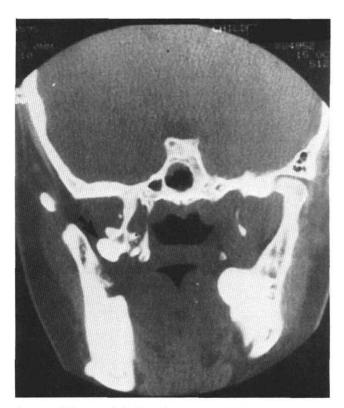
CT scan of skull with arrow pointing to an osteoma located off the lateral and medial pterygoid plate in the maxillary sinus.
